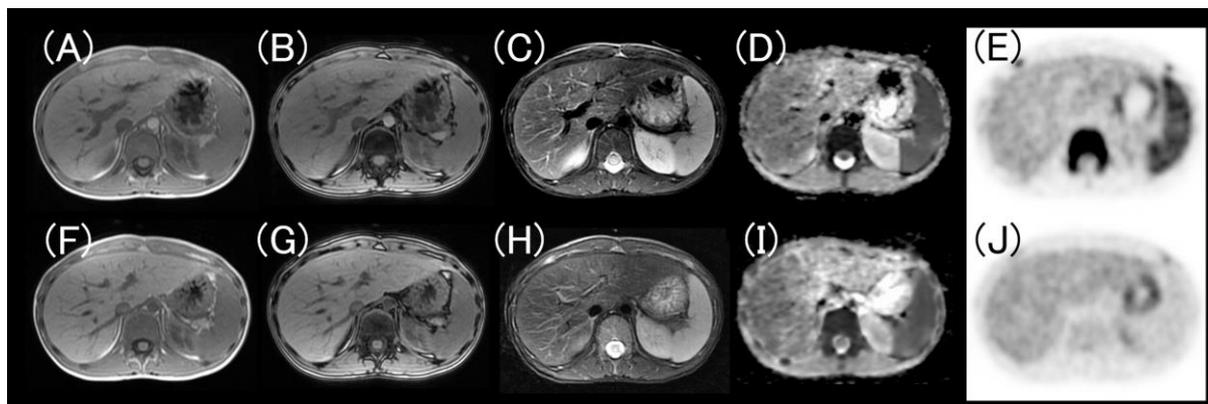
The figure shows axial images of the in/opposed phase of T1 weighted-images (WI) , fat-suppressed T2WI, apparent diffusion coefficient (ADC) map, and the FDG PET of PET/MRI performed one day (A to E, respectively), and 21 days (F to J, respectively) after G-CSF administration. At one day after G-CSF, MRI showed normal signal intensity (ratio of signal intensities of bone marrow to erector muscle on T2WI, 0.73; ADC, $2.5 \times 10^{-3} \text{ mm}^2/\text{sec}$) (A to D), whereas PET showed increased FDG uptake of bone marrow (SUVmax, 7.7) (E). High signal intensity on T2WI and increased ADC were found 21 days after G-CSF (T2WI ratio, 1.61; ADC, $5.2 \times 10^{-3} \text{ mm}^2/\text{sec}$) (H and I); however, FDG uptake reduced to normal level (SUVmax, 1.3) (J). No signal changes were seen on T1WI in both examinations (A, B, F, and G).
